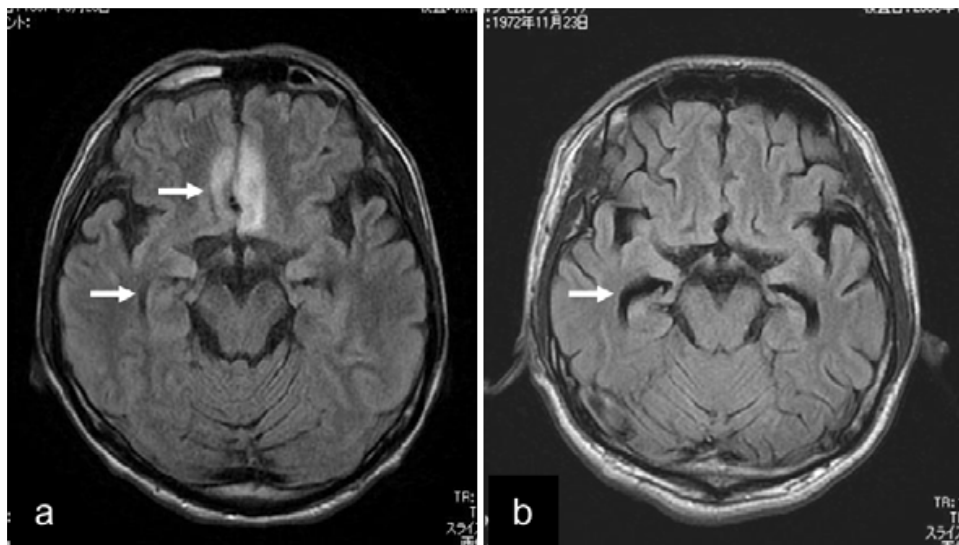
a,b: MRIs of Patients 1 & 2 with NHALE at the recovery stage; a: an axial fluid attenuated inversion recovery (FLAIR) MRI of Patient 1 reveals hyperintensity lesions in the rectus gyri, and mild dilatation of the inferior horn. b: an axial FLAIR MRI of Patient 2 shows moderate dilatation of the inferior horn.
